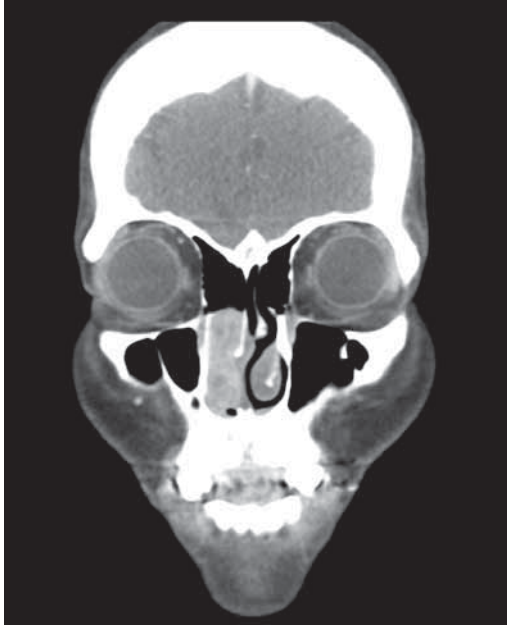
CT scan showed a $2.8 \times 3.2 \times 1.1$ cm soft tissue tumor in the right middle meatus at medial aspect abutting the nasal septum and protruding to the inferior nasal cavity without maxillary antrum involvement.
